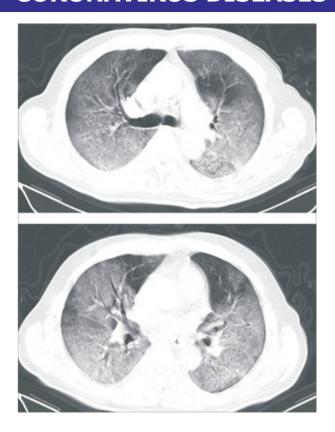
High resolution image of transverse CT scan showing extensive ground glass opacities in both lungs giving a white lung appearance Courtesy: Lancet Inf Dis Feb 24, 2020 http://doi.org/10.1016/S1473.3099)2-_30086
